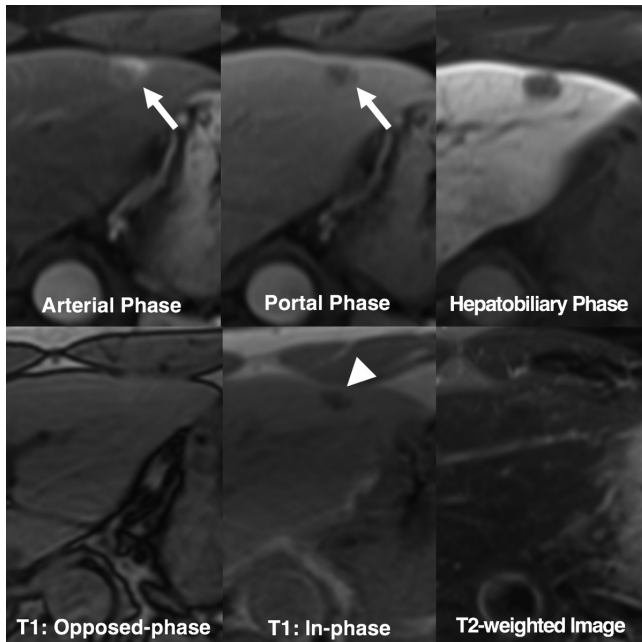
Benign lesion initially categorized as LR-5 but correctly downgraded by applying ancillary features. 52-year-old HBV carrier underwent gadoxetate-enhanced MRI after hepatic nodule was found on ultrasonography. 1.4-cm nodule in left liver shows arterial hyperenhancement (arrow) and washout appearance on portal phase (arrow). Two reviewers considered arterial enhancement as rim-like and categorized nodule as LR-M. Other reviewers initially categorized nodule as LR-5. Nodule shows signal drop from opposed-phase to in-phase of T1-weighted gradient-recalled echo sequence (arrowhead), indicating presence of intralesional iron deposits. Note that nodule shows isointensity on T2-weighted image. These features are uncommon finding in progressed HCCs. After applying these ancillary features, reviewers downgraded their categories to LR-4. This nodule was confirmed as angiomyolipoma after hepatic resection.
